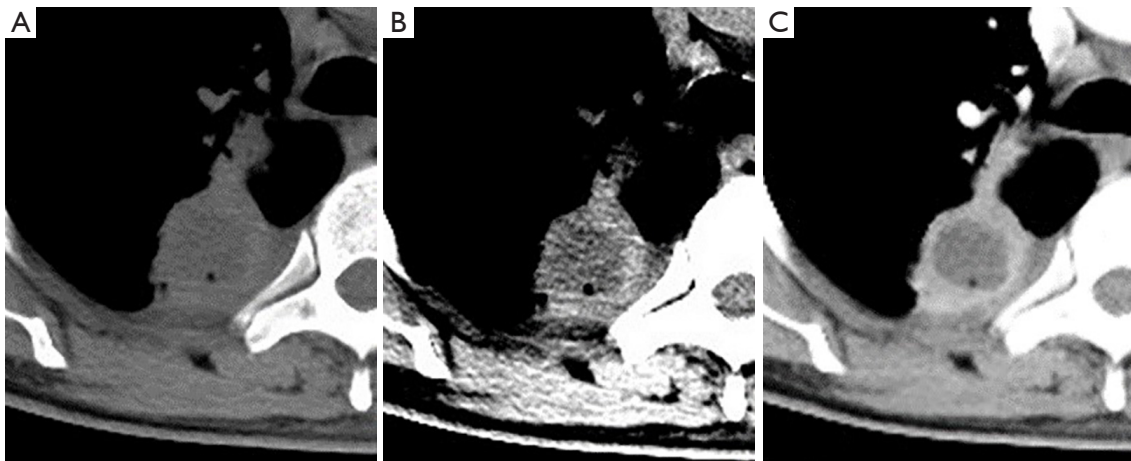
HyS on plain and contrast-enhanced CT scans. The plain CT scan shows a round and well-defined mass in the right lower lobe with pleural thickening; an ill-defined focal area with slightly lower attenuation; and a small vacuole is detected in the mass on standard mediastinal window (A), but it is clearer on the narrow mediastinal window (B). A well-defined and round HyS with Δ CT of 3.5 HU can be observed on the contrast-enhanced image (C). Pathologically, it consists of significant fibrous tissue and massive chronic inflammatory cells accompanied by localized abscess. Δ CT = peak CT value measured on enhanced images – CT value measured on plain CT scan. CT, computed tomography; HyS, hypodense sign; HU, Hounsfield units.
